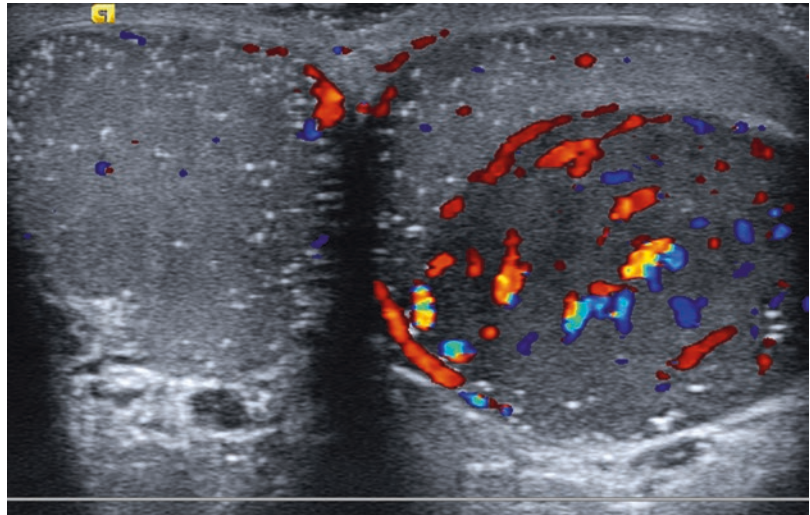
Testicular tumor: transverse color Doppler sonogram shows a large, well-circumscribed hypoechoic mass with prominent blood flow in the left testis and both testes with numerous tiny hyperechoic foci, characteristic of microlithiasis. The mass proved to be a seminoma
